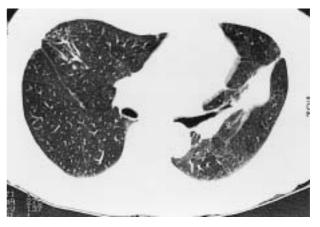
Computed tomography scan showing a dense opacity in the lingular area, along with a nodular infiltrate and streaks over the right middle lobe area.
